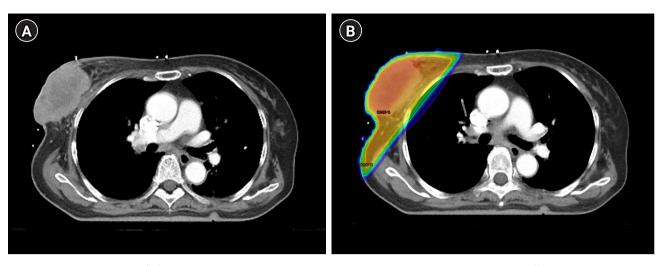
Computed tomograhly (CT) scan and radiotherapy plan for a breast cancer patient with skin involvement. (A) Axial CT image showing extensive tumor involvement in the right breast, including skin invasion. (B) Radiotherapy plan demonstrating the treatment field for the same patient. The radiation dose distribution is depicted with color wash. The patient received 45 Gy in 15 fractions in total.
